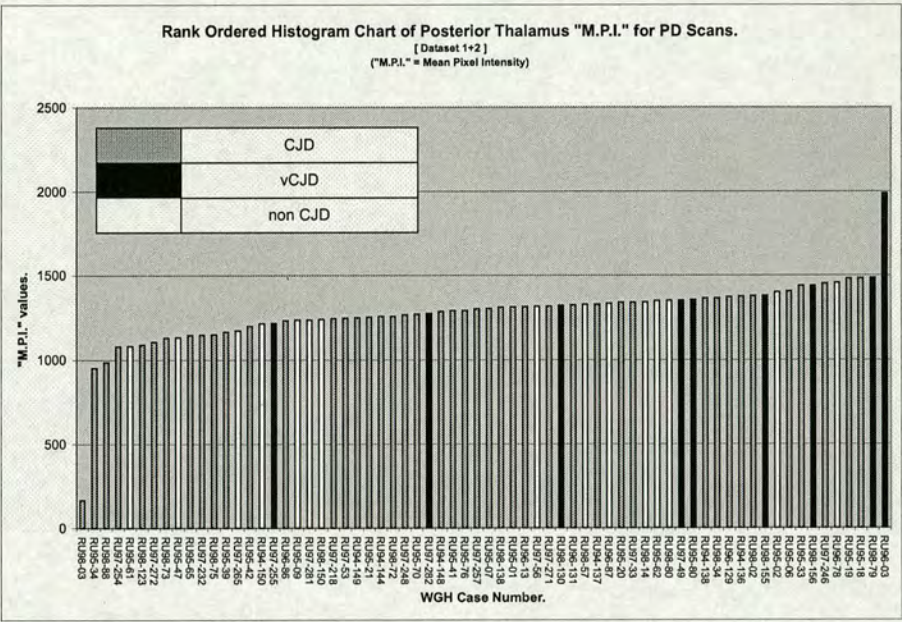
Posterior Thalamus Tests: Rank ordered histogram of the Posterior Thalamus region "M.P.I." values for the PD weighted MRI scan-data from datasets 1 & 2 combined.
